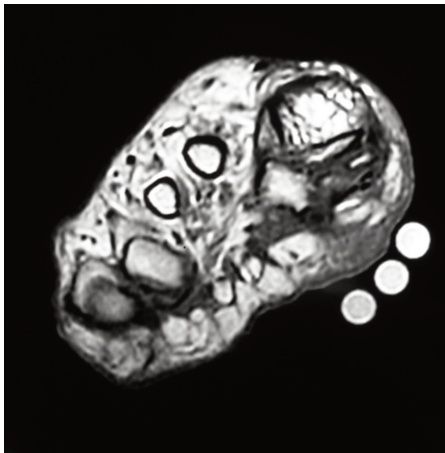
T1-weighted image of a plantar fibroma.
